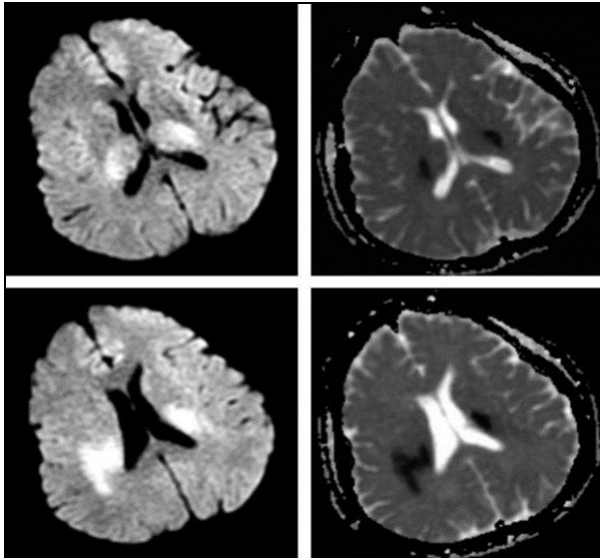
DWI and ADC imaging taken at the time of admission to the emergency department (Hyperintense lesions are clearly observed).
